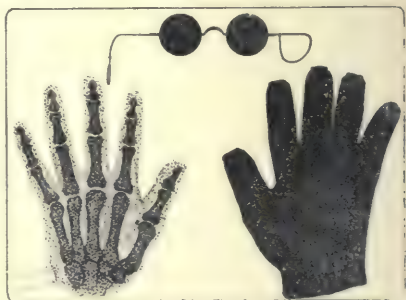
A radiograph of spectacles and of gloves opaque to X-rays.
